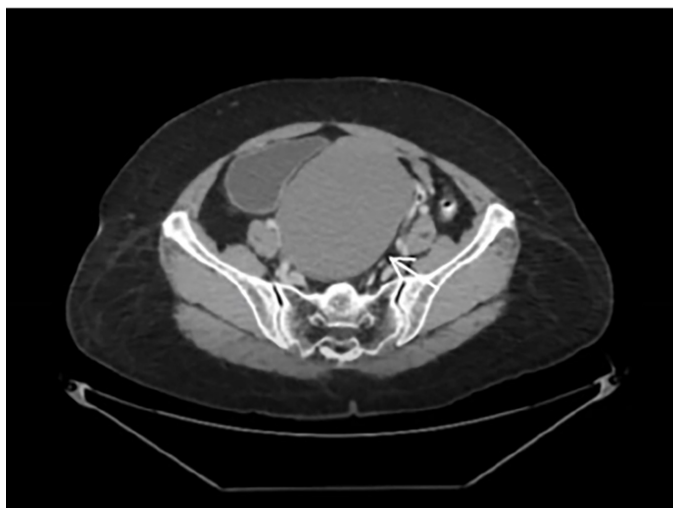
CT scan showing a large pelvic mass which was initially thought to arise from the posterior wall of the uterus causing local mass effect (white arrow).
